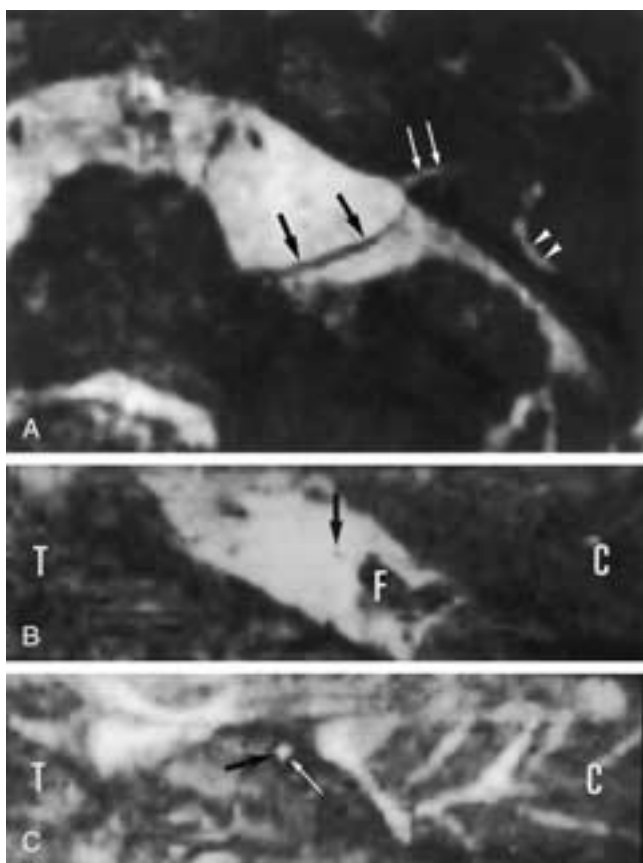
Type 1 malformation, aplasia of the VCN with a stenotic IAC in a patient presenting with complete congenital deafness. A, Axial 0.7 mm thick T2-weighted gradient-echo image through the left inner ear. A very narrow fluid-filled IAC can be seen (*long white arrows*). On the axial images only a single nerve, the facial nerve, can be found in the left cerebellopontine angle (*large black arrows*). Normal fluid in the common crus (*white arrowheads*). B and C, Parasagittal T2-weighted gradient-echo images perpendicular to the course of the nerves at the level of the left cerebellopontine angle (B) and IAC (C). B, In the cerebellopontine angle, only the facial nerve (*large black arrow*) can be seen anterosuperior to the floccle (*F*). C, Only a little CSF can be visualized inside the very narrow IAC (*large black arrow*). Nerves are difficult to visualize in such a narrow IAC. Here the facial nerve can be depicted lying against the posteroinferior wall of the IAC (*long white arrow*). The VCN is absent. *C*, Cerebellum; *T*, temporal lobe.
